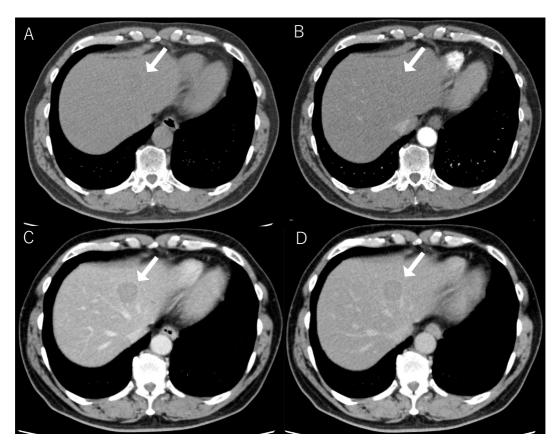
Computed tomography. A 3-cm low-density nodule is located in the medial segment of the liver (white arrow). The contrast effect is indistinct in the arterial phase (B), while a very mild contrast effect is observed from the portal phase (C) to the equilibrium phase (D).
